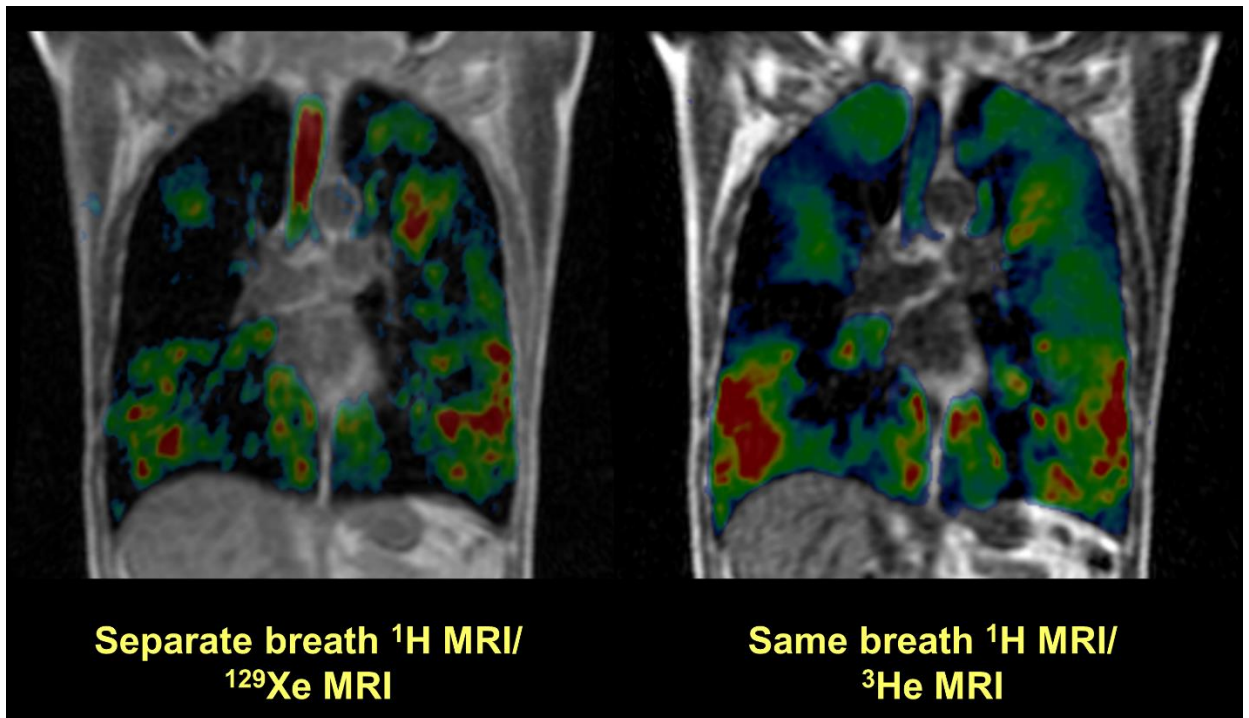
Coronal slices for ^{129}Xe and ^3He fused with their corresponding same breath and separate breath anatomical ^1H MR images, respectively.
